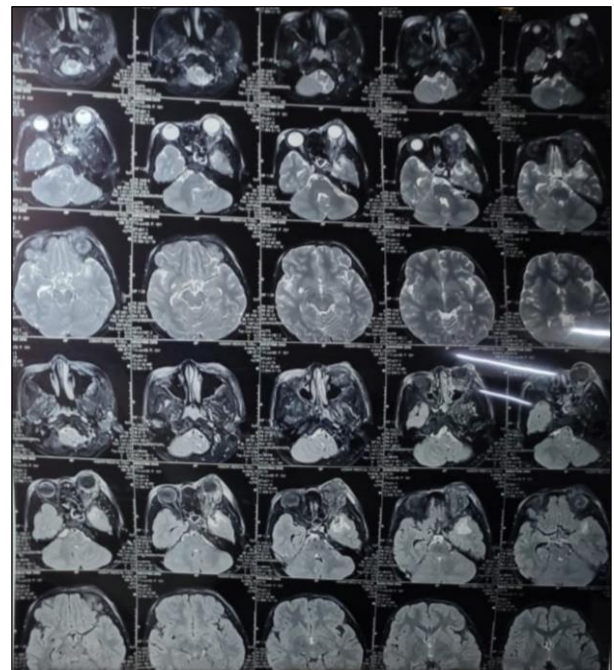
MRI scan of the patient.
